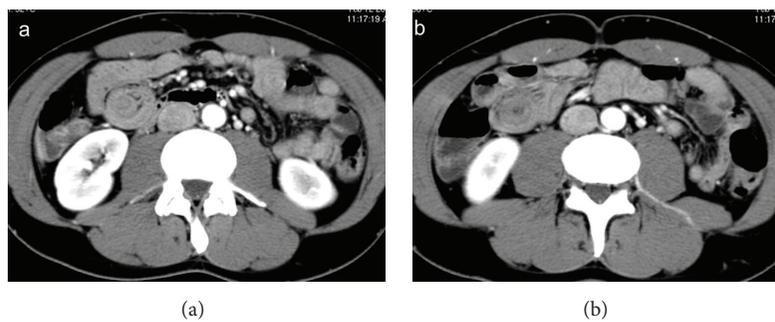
Enteroenteric (ileoileal) intussusception. Target-like mass on axial CT images. Transient intussusception with no signs of intestinal obstruction or intestinal ischemia.
